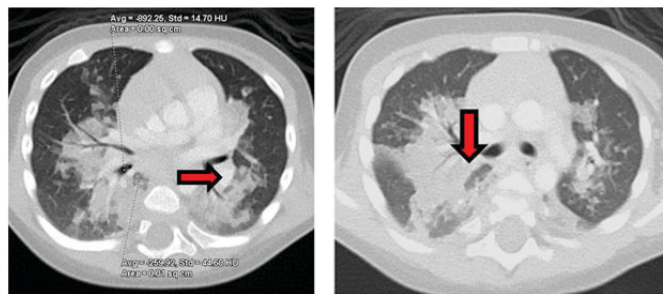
Chest CT scan showed bilateral lung consolidation with interspersed areas of low attenuation are shown (red arrows), with an average Hounsfield unit of -260 relative to air, $HU = -892$.
